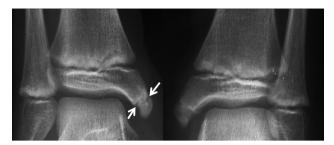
AP radiographs of both ankles. An accessory ossification centre of the medial malleolus is present bilaterally. On the right, symptomatic side, there is a fragmented appearance of the tip of the medial malleolus (arrows), and slight detachment as opposed to the contralateral side.
